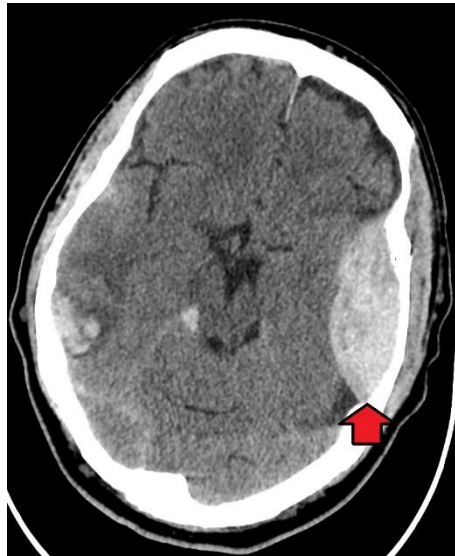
axial CT of an extradural hematoma caused by a fracture
